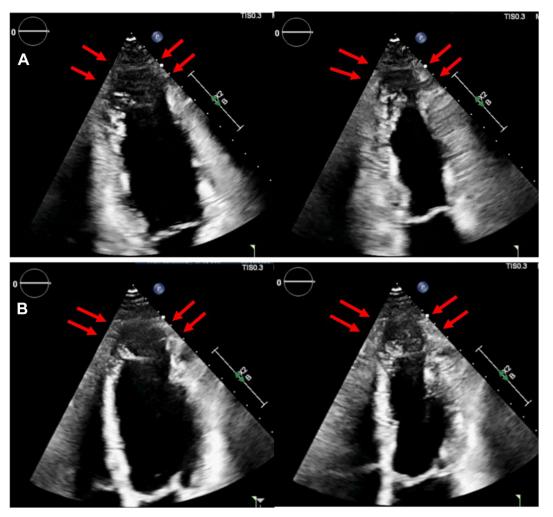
Two-dimensional TTE, apical 2-chamber (A) and apical 2-chamber (B) views in diastole (*left*) and systole (*right*), demonstrates the normal global LV systolic function with a focal LV apical dyskinetic outpouching segment with a relatively wide neck (*red arrows*).
